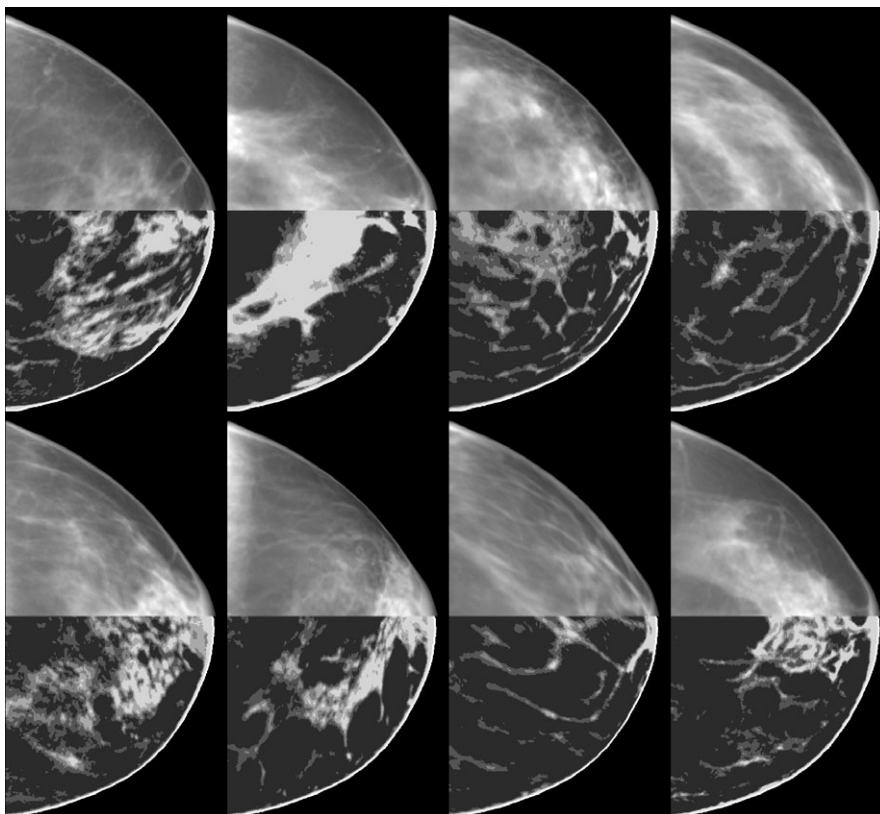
Sample training cases, from the 8 cm cluster, shown as a simple projection (without x-ray physics) in the top half and a central slice of the volumetric image in the bottom half. Only a subset of the 40 training breasts are shown.
